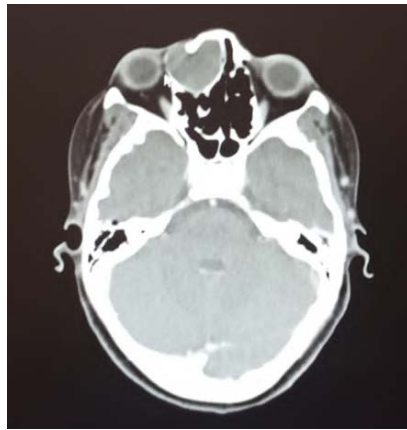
Axial CT scan showing the frontoethmoidal mucocele.
